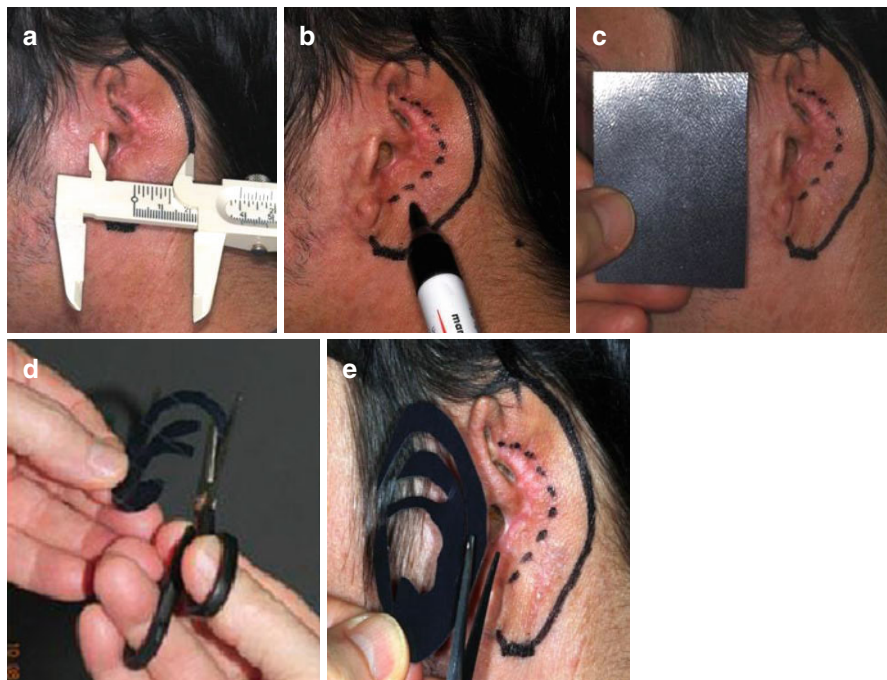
Surgical planning and demarcation before surgery: (a) through the use of a paquimeter, the size and shape of the future ear are established; (b) the location and position of the future auricle are marked taking as reference the opposite ear when it is normal. (c) The model of the future auricular skeleton is carefully created using x-ray film; (d, e) the model is then placed into the area of the projected auricle
